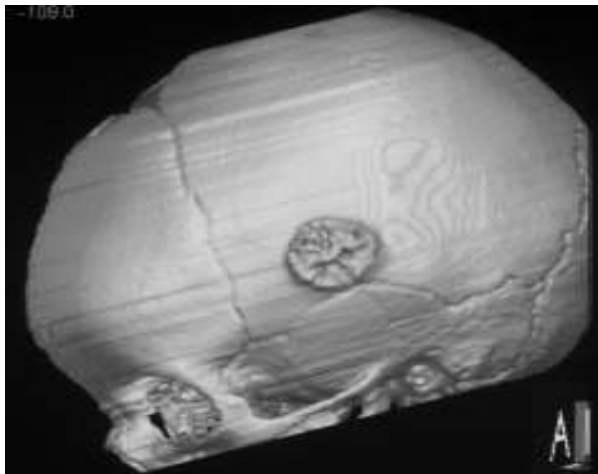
3D computed tomography showing a mass lesion in the left parietal bone.
